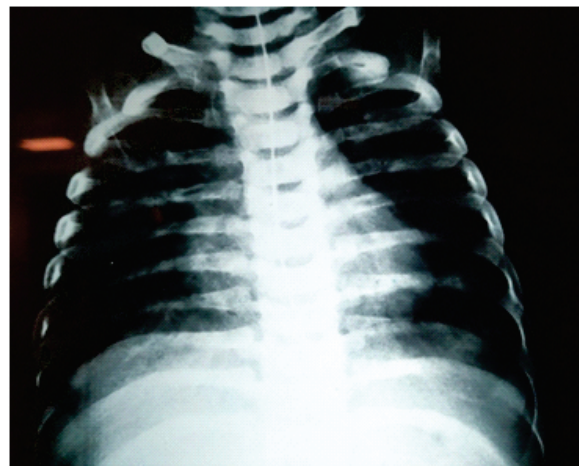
X-Ray Chest -Post therapy with Valganciclovir
